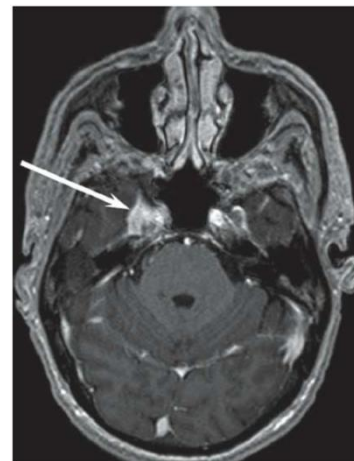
Axial MRI shows a stinging mass (arrows) in the cavernous sinus and right medial cranial fossa, depicting direct spread of the NPC mass.
